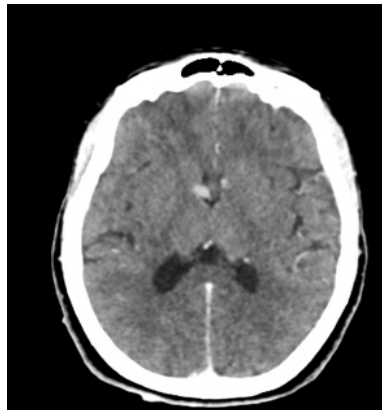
CT scan of the brain in axial slices showing two well-defined, oval-shaped extra-axial subependymal formations, hyperdense, containing calcifications, suggestive of hamartomas.
